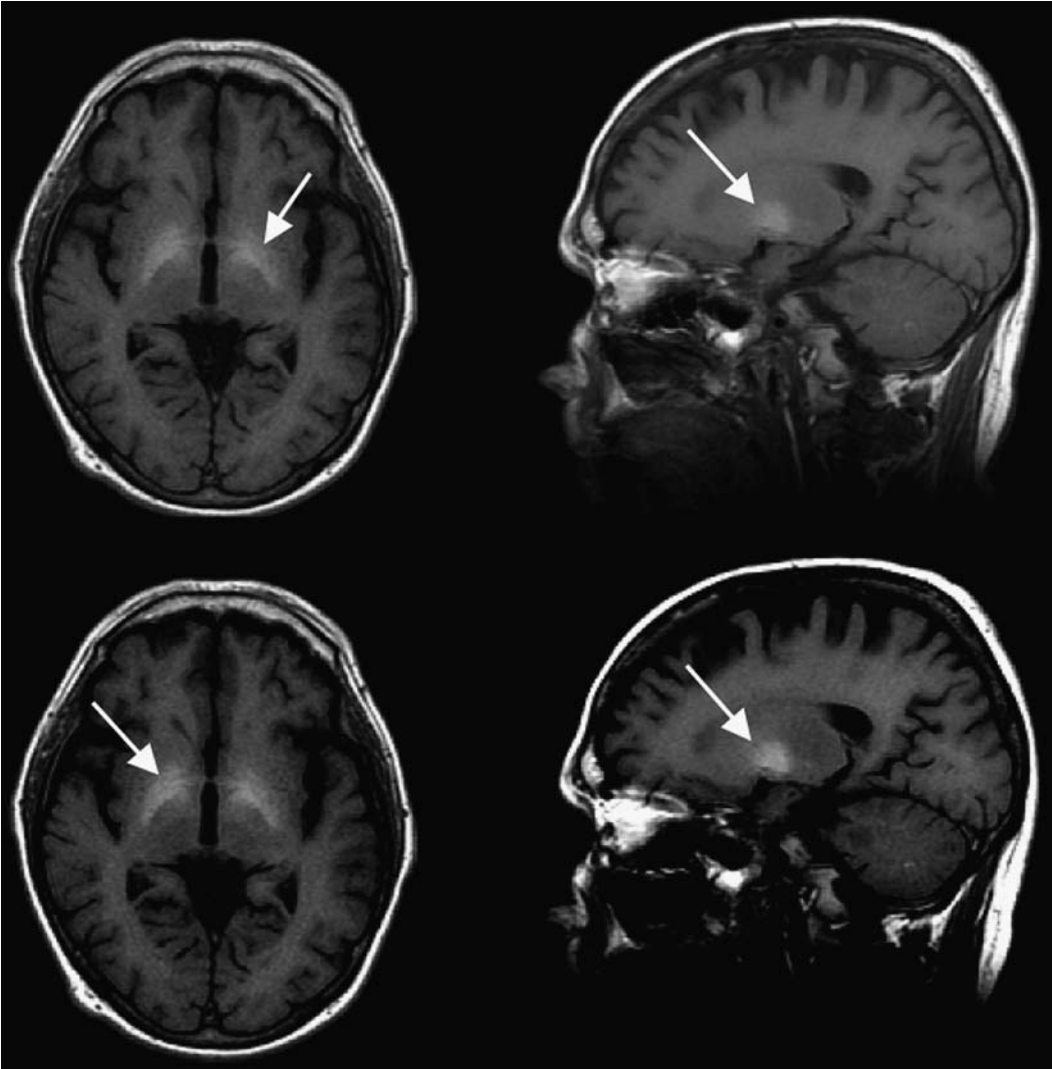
Hyperintensity of the globus pallidus (arrows) on a T1-weighted series (axial—*left* and sagittal—*right*) from a patient with alcohol-related cirrhosis of the liver.
